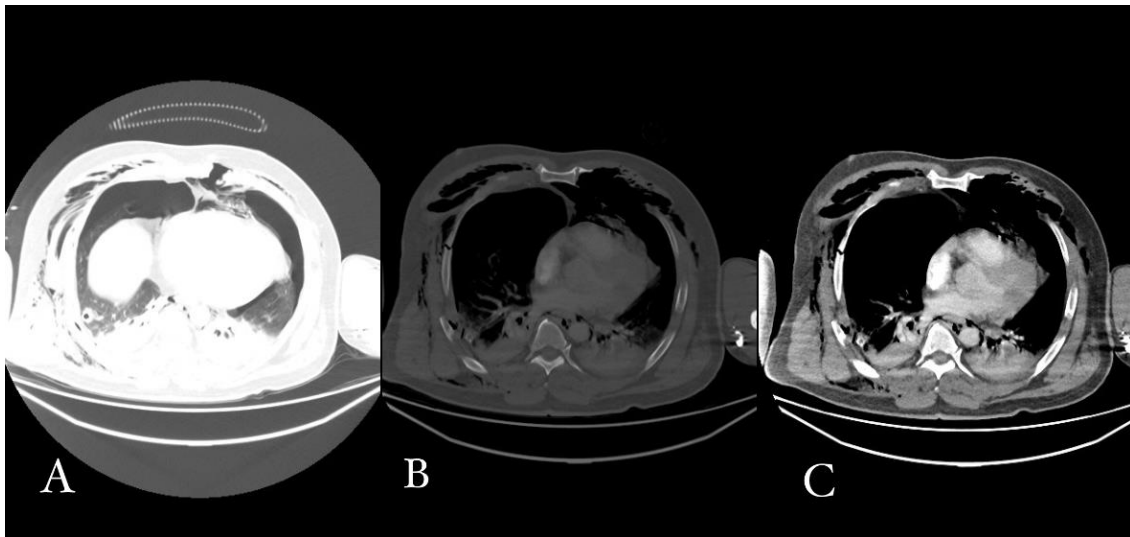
CT scan with polytrauma protocol in patient after car accident. Clinically, he was positive on chest injury and skeletal trauma. There is a sign for bilateral lung contusion with partial pneumothorax and bilateral subcutaneous emphysema, more pronounced at the right side (A, B) with rib fractures at several ribs on the right hemithorax (C)..
